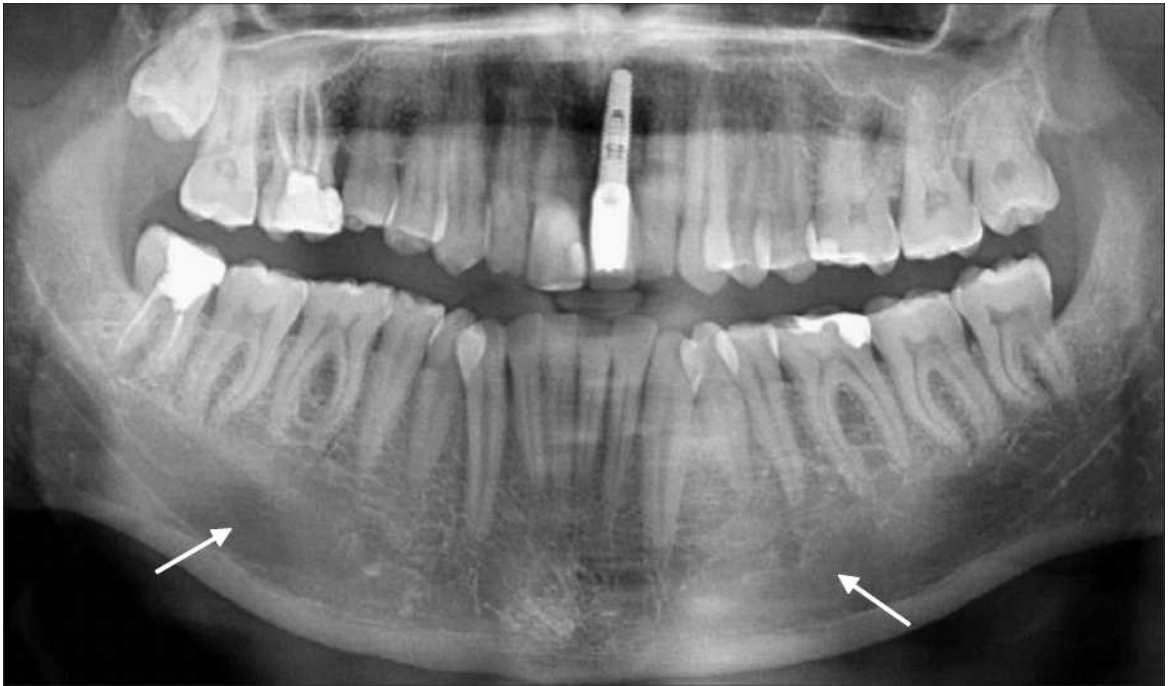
2.8 The orthopantomograph shows the disrupted superior border of the mandibular canal (arrows) and cancellous bone which has few and thin trabeculae (Juodzbaly and Wang, 2010).
